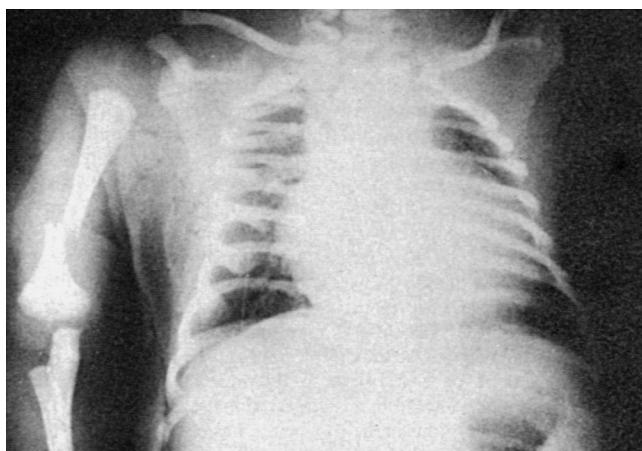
Chest radiograph of a vaginally delivered, full-term infant (4.7 kg) of a diabetic mother. The infant had cardiomegaly, hepatomegaly, congested lung fields, and fractures of the right humerus and left clavicle.
